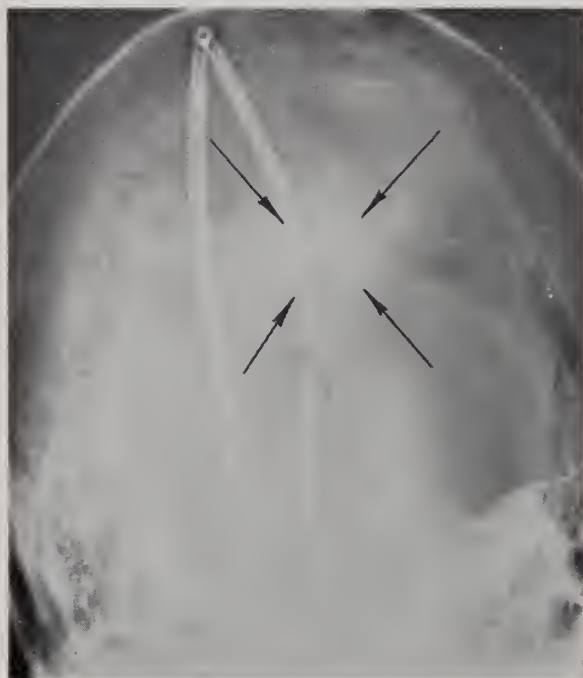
Case 9. The arrows delineate a calcified mass in the pineal region in this roentgenogram. The linear shadow is the tube used to bypass the third ventricle.
